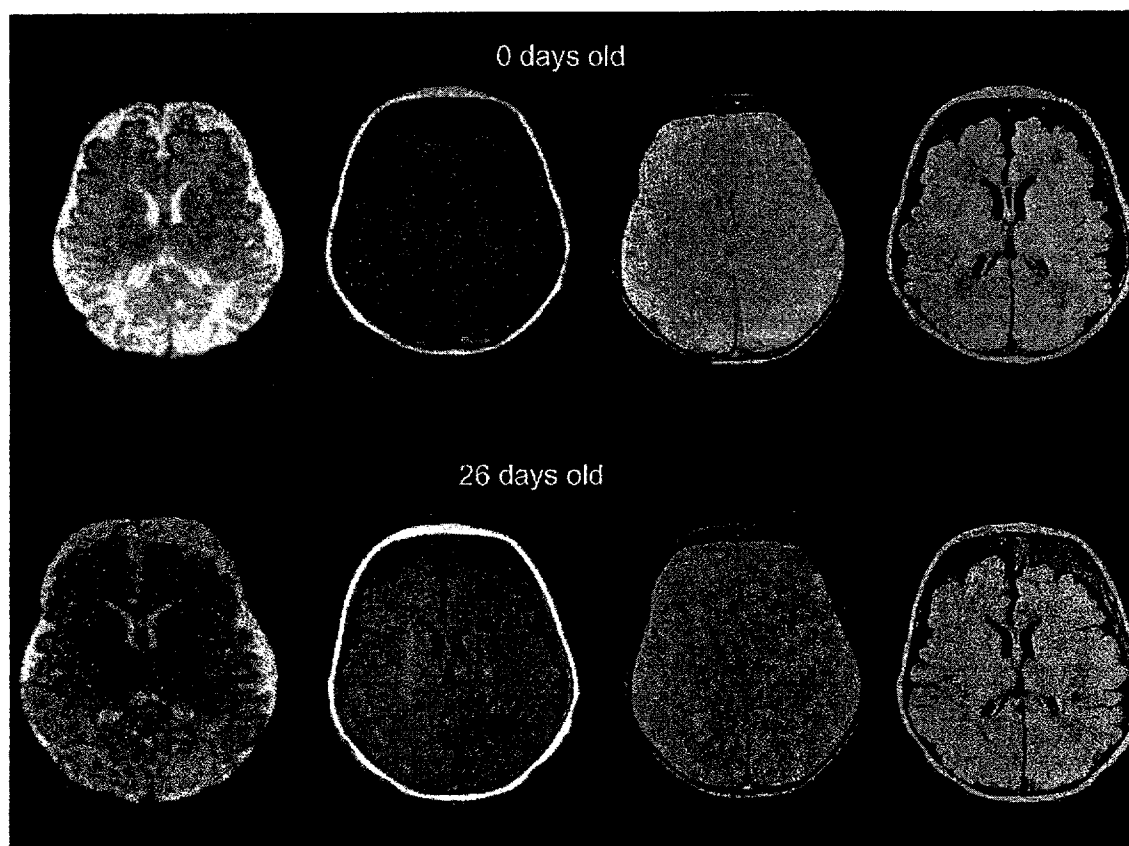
Images obtained from an infant with benign extracerebral collections of infancy and spontaneous subdural hemorrhage. Axial T2, T1, GRE, and FLAIR images (left to right) show CSF-intensity frontal subarachnoid collections at birth (top row). At 26 days postnatal age (bottom row), superimposed subdural collections that don't conform to CSF signal are present (courtesy of Veronica J. Rooks, MD, Tripler Army Medical Center, Honolulu HI).
